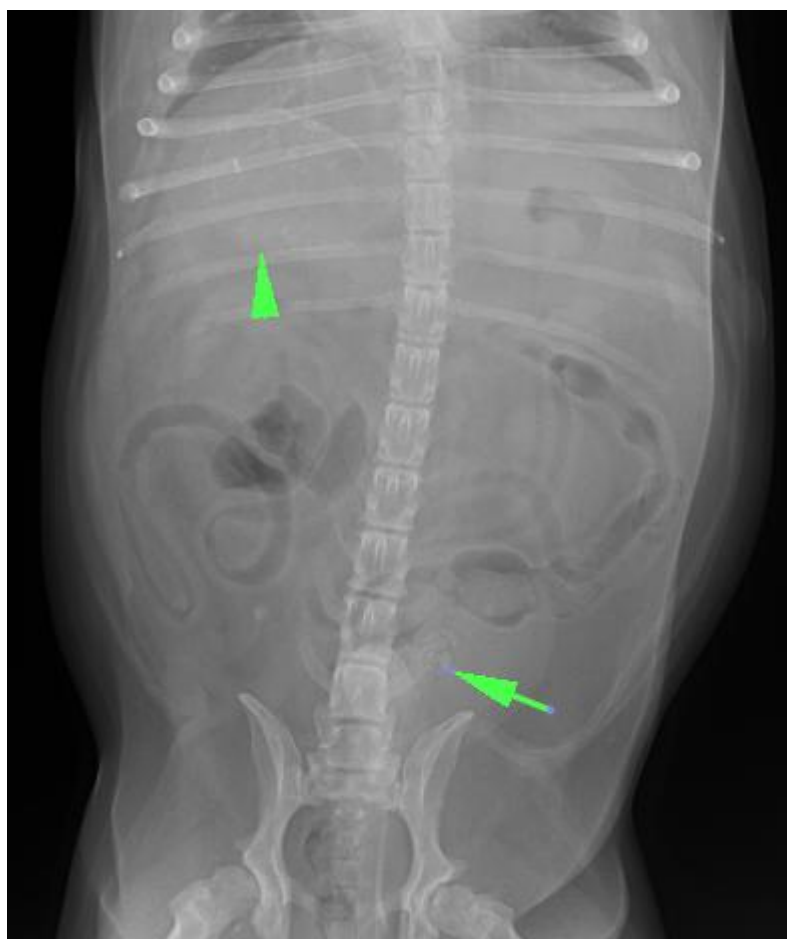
The ventrodorsal abdominal view of the abdominal radiograph showed that the gastric axis was perpendicular to the spine at the 12nd thoracic vertebrae. The hepatic edges at the right and left latero-caudal showed the sharp margin. There was evidence of an oval-ring shape, faint mineralization (4.4 x 5.2 cm, arrow head). Moreover, at the mid-caudal abdomen revealed a moderate amount of radiopaque sand calculi in urinary bladder, which the largest diameter was 0.58 cm (arrow).
